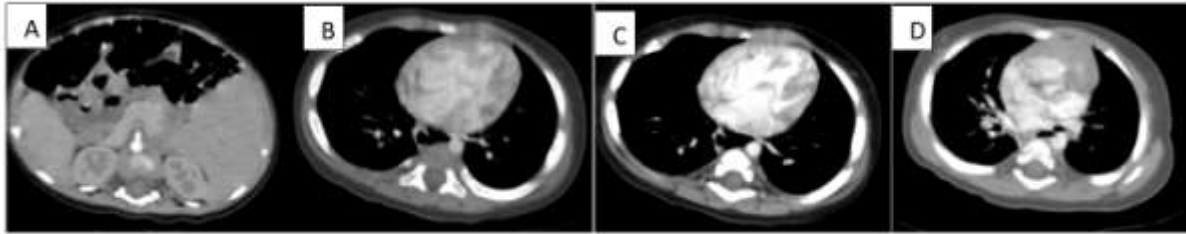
8-month-old with situs ambiguous, TGV, DORV common AV septal defect. Axial CT images depicting - A: Midline liver predominantly in the left half with the head of the pancreas in the left half and spleen in the right half, suggestive of situs ambiguous. B: Common atrioventricular (AV) septal defect and large ostium primum atrial septal defect (ASD). C: Hypertrophied right ventricle and hypoplastic left ventricle with a D-loop. D: Anteriorly placed aorta, valvular pulmonary stenosis, and Double Outlet Right Ventricle (DORV) (supravalvular and sub-valvular pulmonary stenosis also present, not shown in images).
